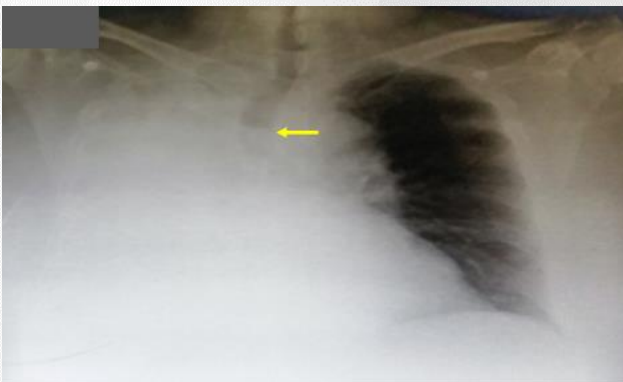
Antero-posterior chest radiograph showing a completely opacified right hemithorax and rightward deviation of the tracheal air column (arrow)
